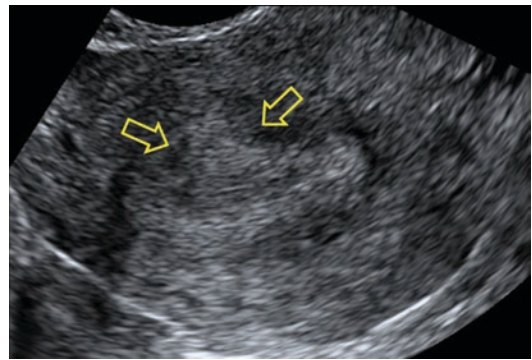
Ultrasound image of adenomyosis: interruption of the junctional zone caused by an echogenic bud
